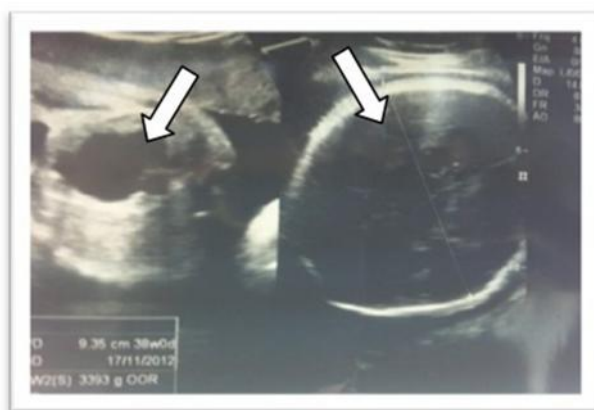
A review of fetomaternal ultrasonography.
